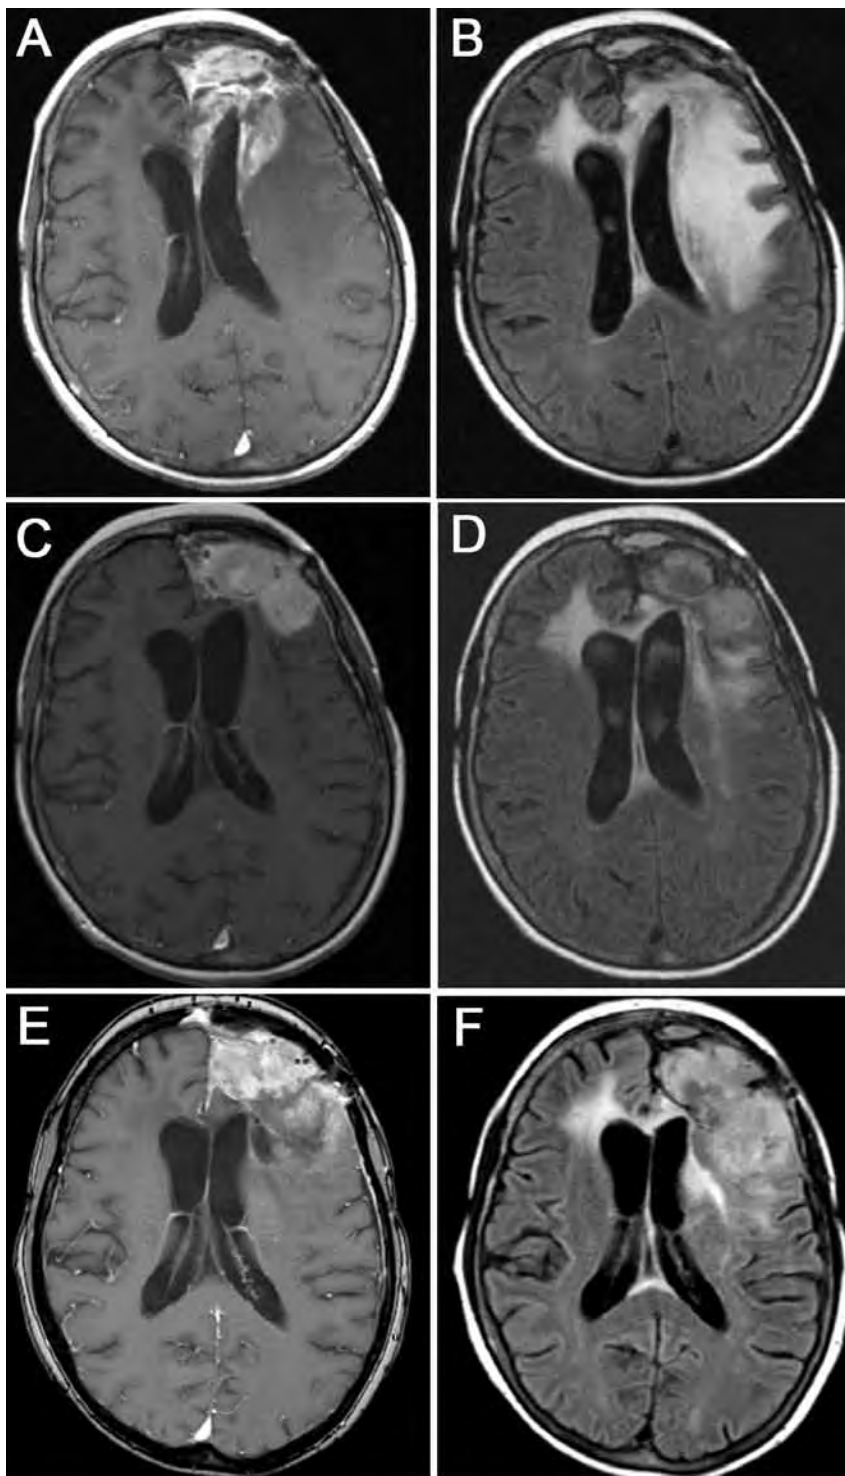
Imaging changes with bevacizumab. This 57-year-old woman presented with a second recurrence of glioblastoma 2 years after chemoradiation and 6 cycles of adjuvant temozolomide and 6 months after 8 cycles of low-dose temozolomide. The images show post-contrast T1-weighted sequences (A, C, E) and fluid-attenuated recovery (FLAIR) sequences (B, D, F). Baseline images (A, B) show a left frontal mass with enhancement, edema, and some mass effect. Eight months later, after 4 cycles of bevacizumab (dosed every 2 weeks with 3 doses per cycle), there is decreased periventricular enhancement and edema (C) and improved FLAIR signal (D) but enlargement of the enhancing left frontal mass, which would meet standard definitions of tumor progression. The patient was neurologically stable and remained on treatment. Nine months later, after 5 additional cycles, she remained neurologically stable (and was not receiving corticosteroids). At this time, the mass has continued to increase in size (note: there is also invasion of the frontal sinus; E), with increasing FLAIR abnormality, likely reflecting a progressive infiltrating nonenhancing tumor (F).
